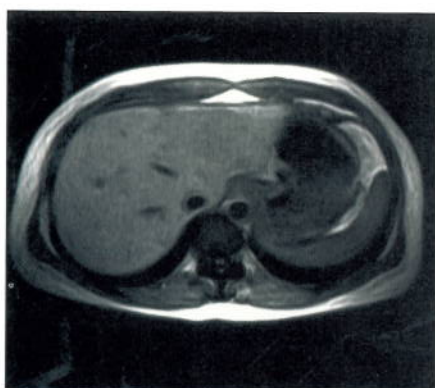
FLASH2D T1-weighted Axial Breath-hold Liver.
